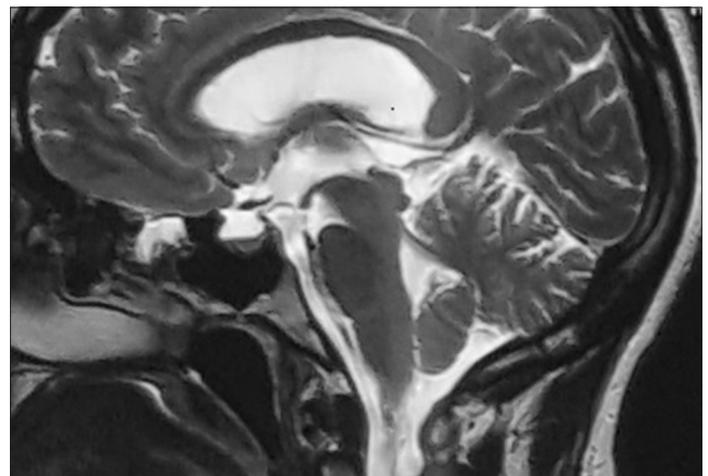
After putting a pressure-regulated lumboperitoneal shunt valve, the cerebral magnetic resonance imaging in sagittal section showed a reascending of the cerebellar amygdala.
